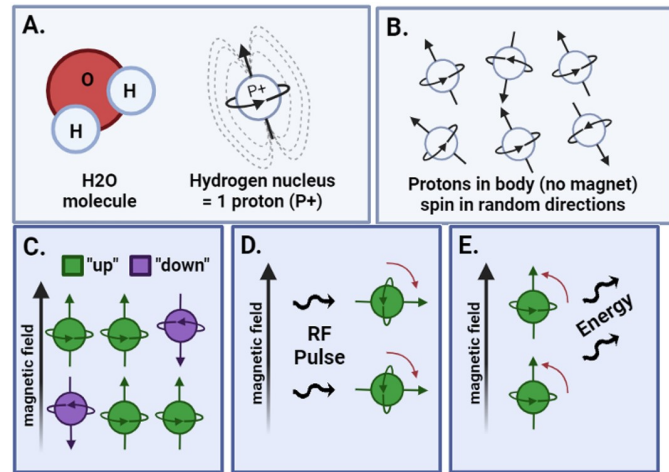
MRI Mechanism. A. Hydrogen atoms of water molecules are involved, which each represent a proton with positive charge. B. Before the magnetic field is active, the protons in the body spin randomly. C. Protons align along their axis with magnetic field of the scanner. D. Turn on radiofrequency pulse; unpaired "up" protons rotate out of alignment. E. Turning off pulse makes protons realign with magnetic field, releasing energy that is measured. Created using BioRender
